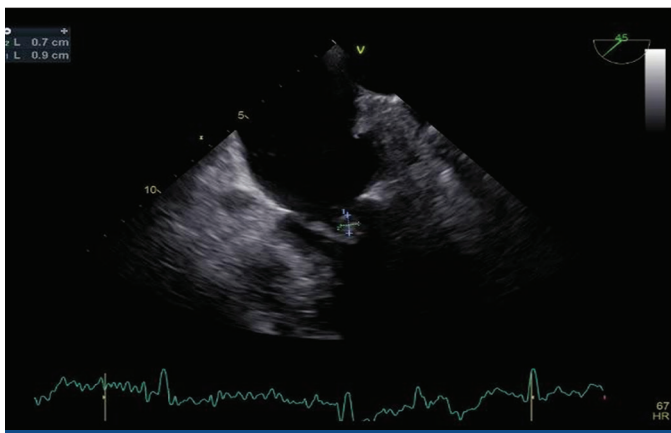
Transesophageal echocardiography showing a vegetation on the anterior mitral leaflet.
